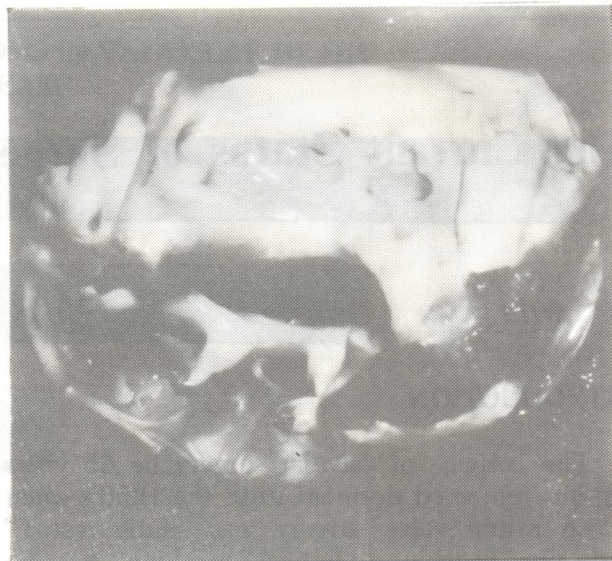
A: Typically stenotic explanted mitral valve. B: X-ray of explanted valve showing heavy calcification
